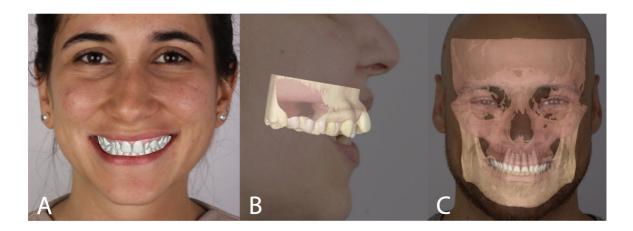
(A, B) STL digital scans orientated, aligned and superimposed onto natural head position photographs. (C) A CBCT DICOM file and an STL digital scan superimposed onto a frontal natural head position photograph.
